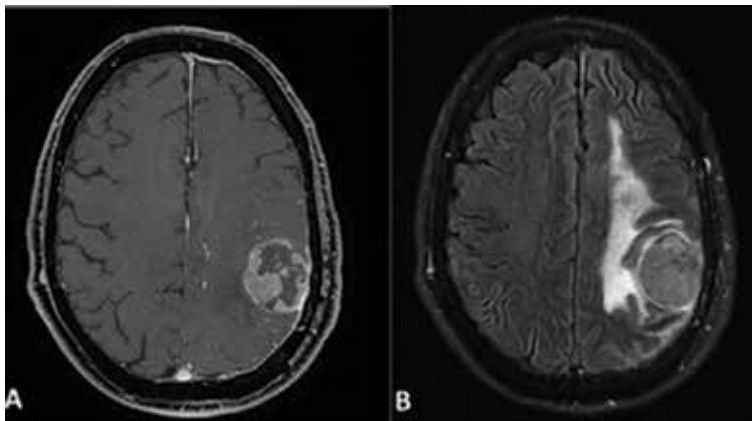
Axial post-gadolinium-DTPA. (A) T1-weighted gradient echo (FSPGR) showing irregular contrast enhancement and tumoral necrosis. (B) Axial FLAIR magnetic resonance evidencing extensive peritumoral edema with changes in radiological aspect from original tumor.
